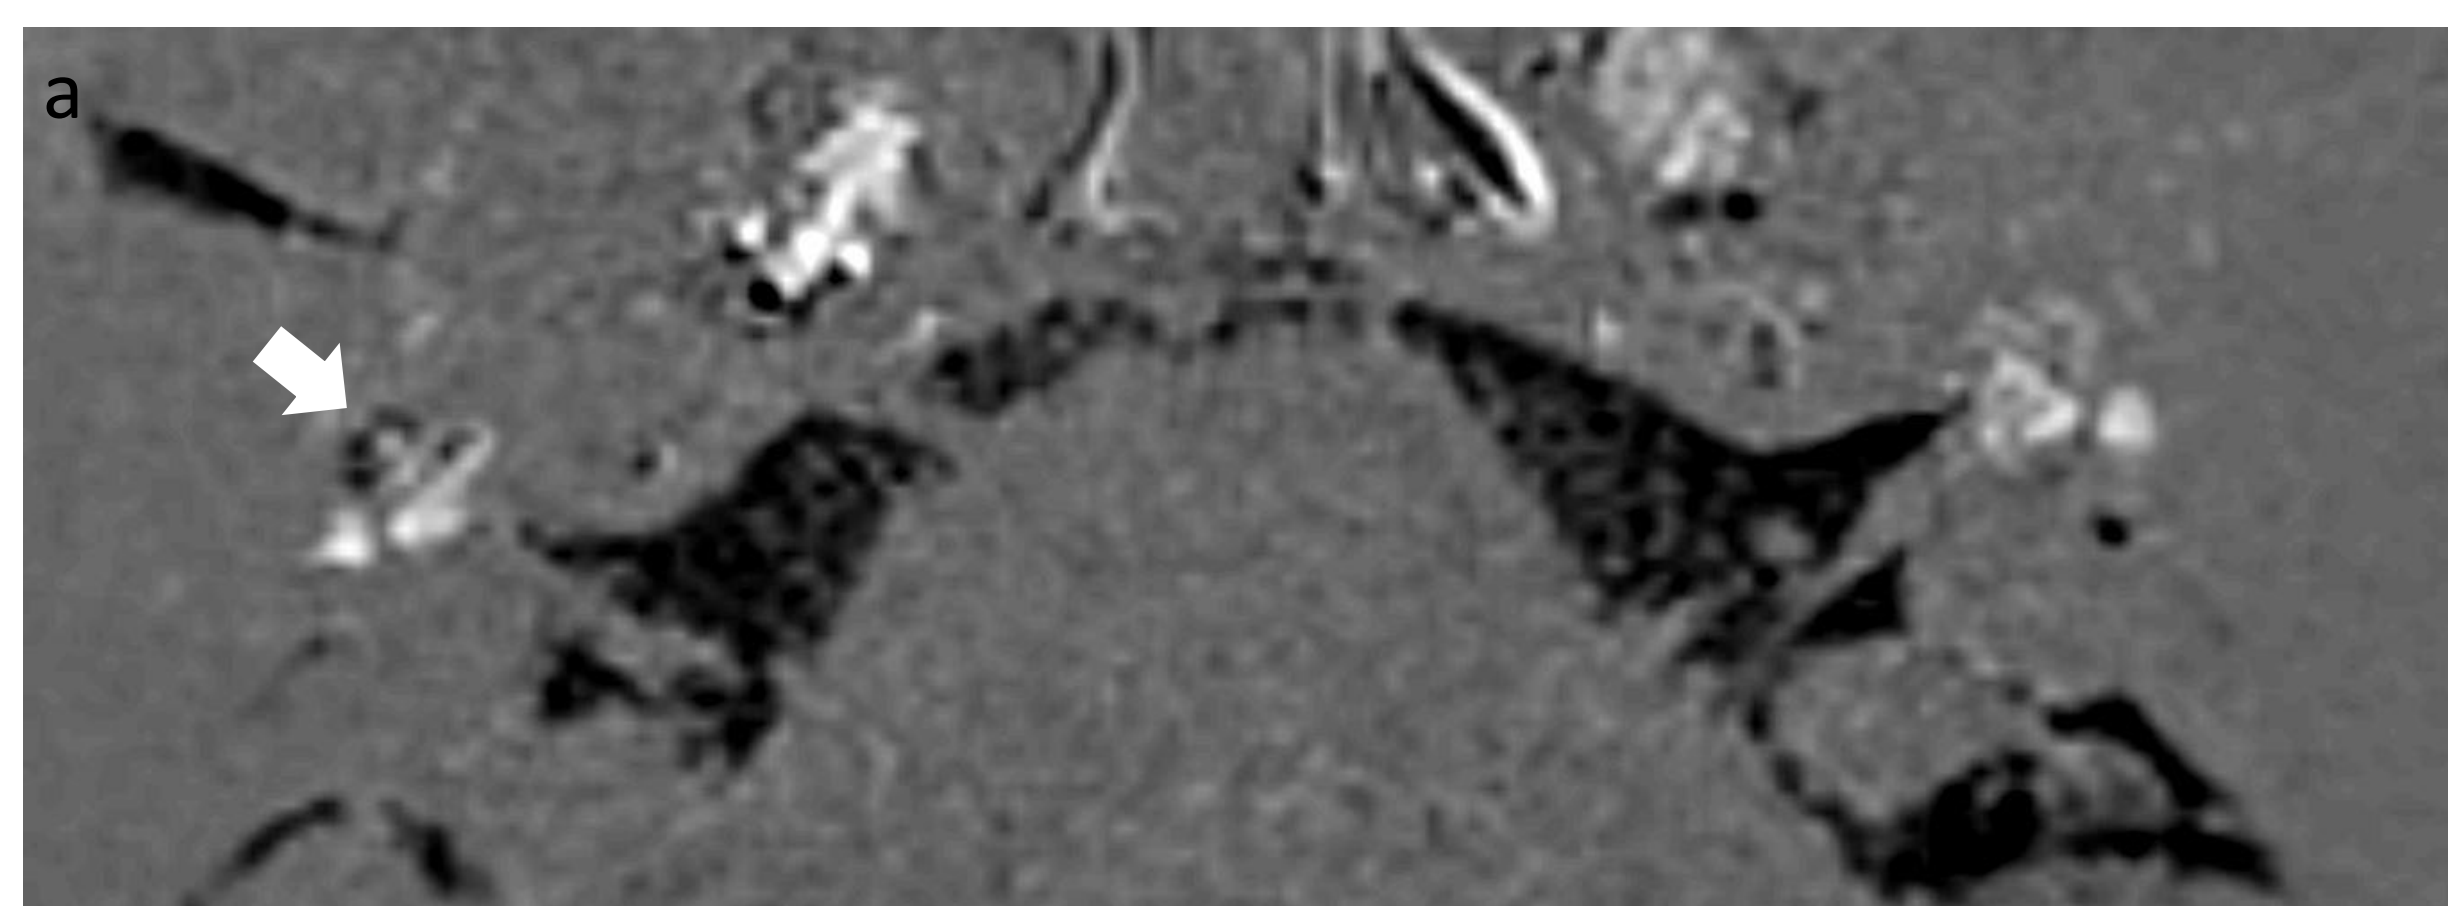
Subtracted images of T2 weighted delayed post contrast FLAIR MRI. Axial images taken at the levels of the cochlea (a), saccule (b) and utricle (c). Cochlear hydrops is identified by an arrow on images a and b. Image b shows absence of saccule hydrops. Image c shows absence of utricle hydrops.
